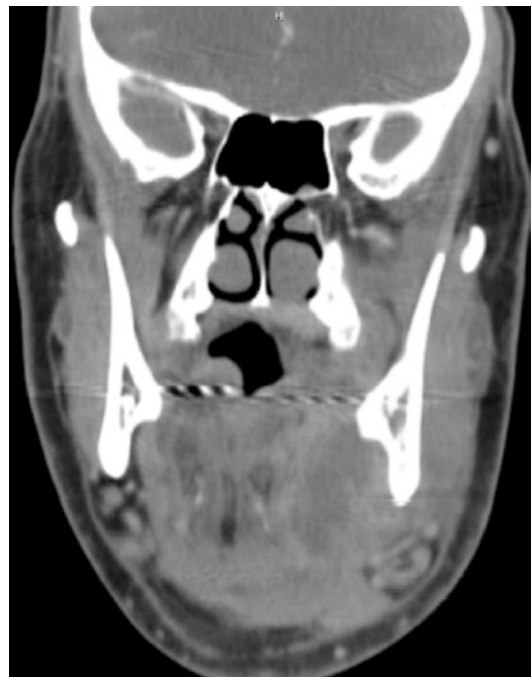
CT scan with contrast at the level of the pterygoid plate. (Image courtesy of Dr. Damian Findlay)
